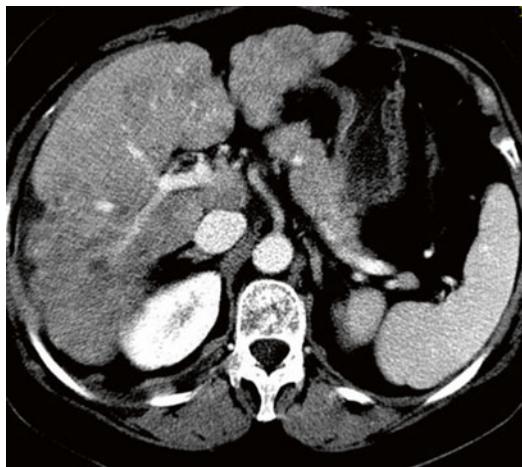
Axial post-contrast CT image of a 57-year-old female with metastatic breast carcinoma, showing multiple hepatic ill-defined metastases, hepatic nodularity, heterogeneity, and capsular retraction consistent with pseudocirrhosis
